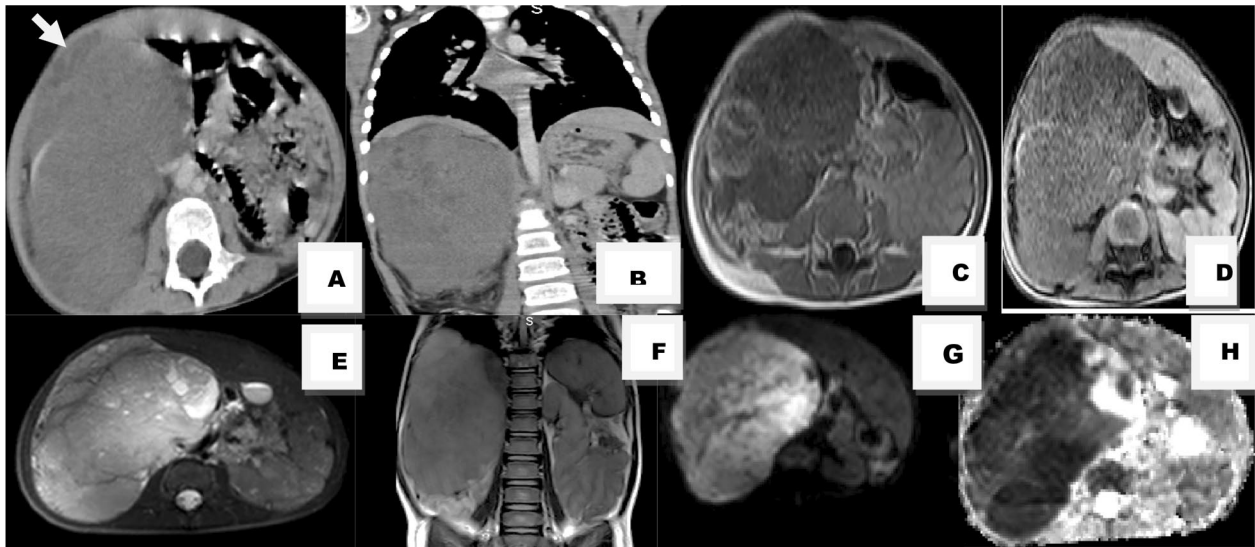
Comparison between CT, MRI diagnosis and pathology
